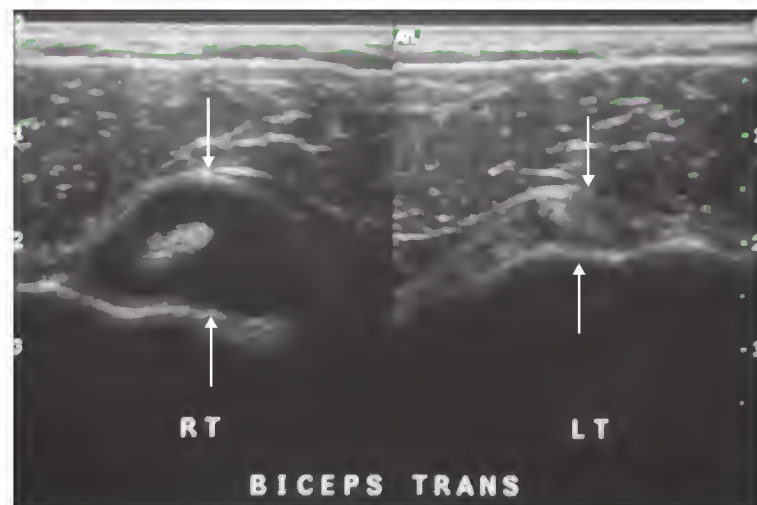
Ultrasound of bicipital tendinitis. A transverse image shows a large effusion (arrows) in the long head of the biceps tendon sheath.
